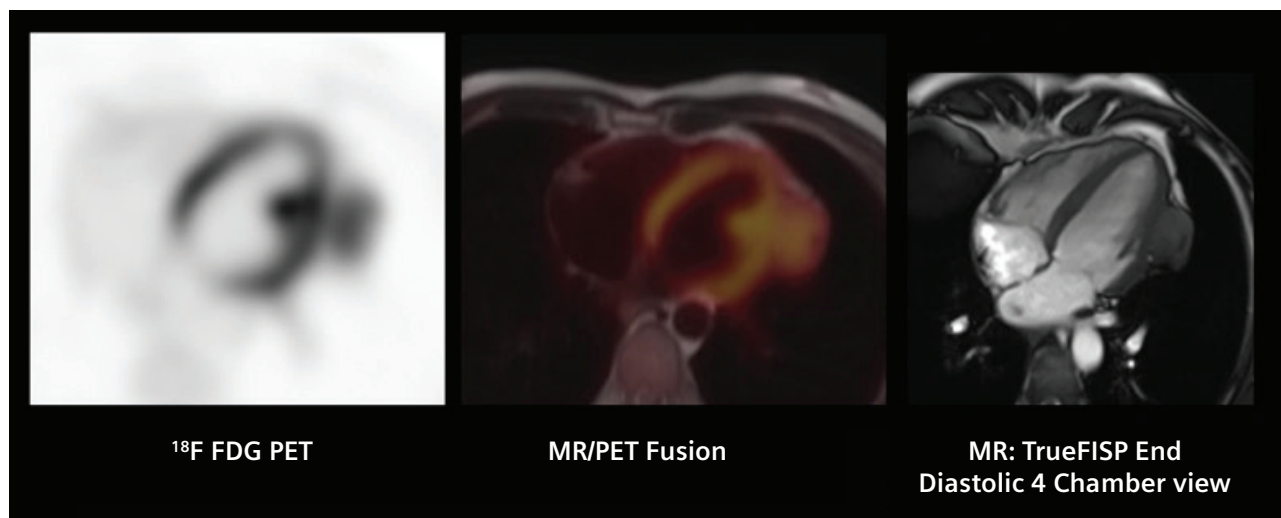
4-chamber view of  $^{18}\text{F}$  FDG PET, MR and PET/MR fusion shows a hyper-metabolic pericardial mass in the lateral wall of the LV.
